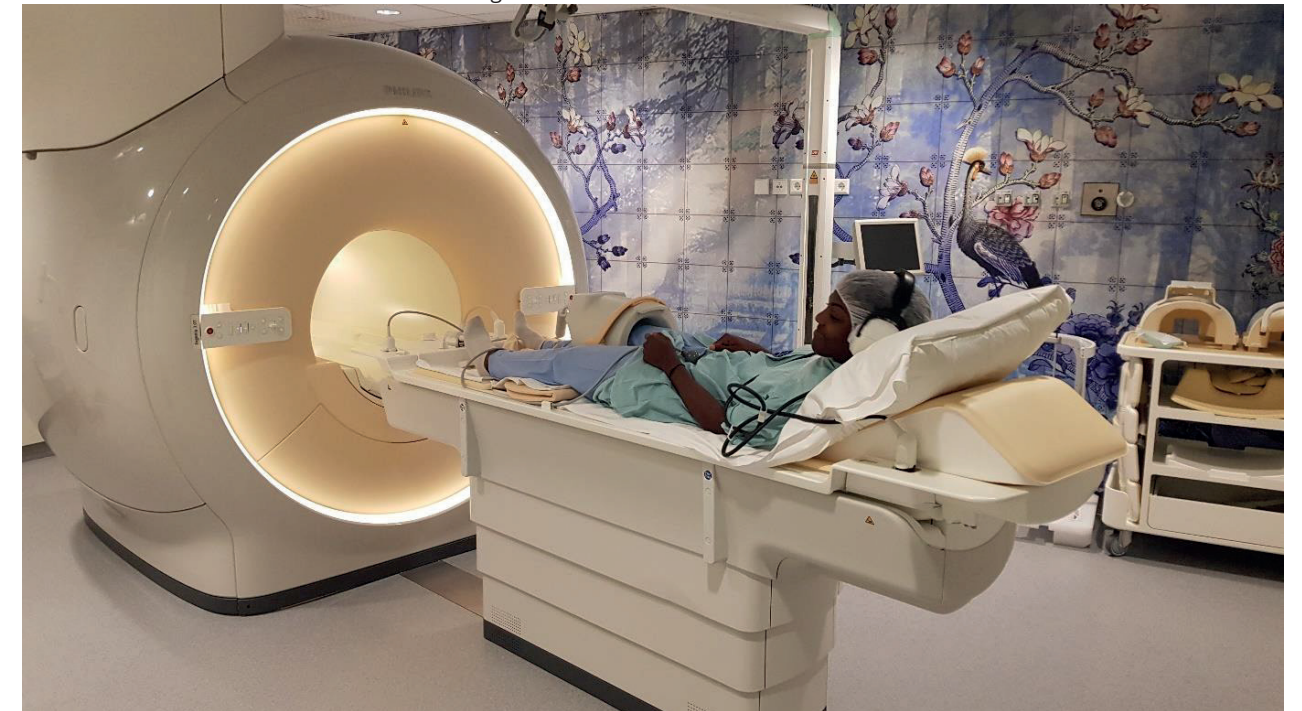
Researcher inside MRI scanner for knee imaging
